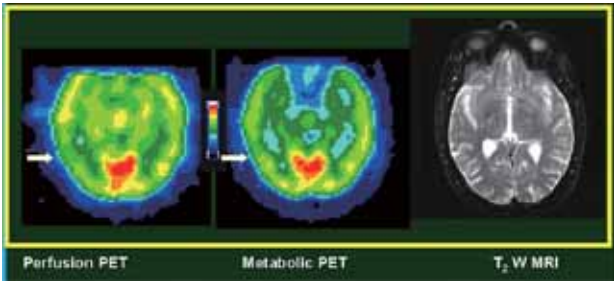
A patient with closed head injury but without loss of consciousness has normal MRI and perfusion and metabolic PET (one color interval = one standard deviation with mean in the center of the scale).
